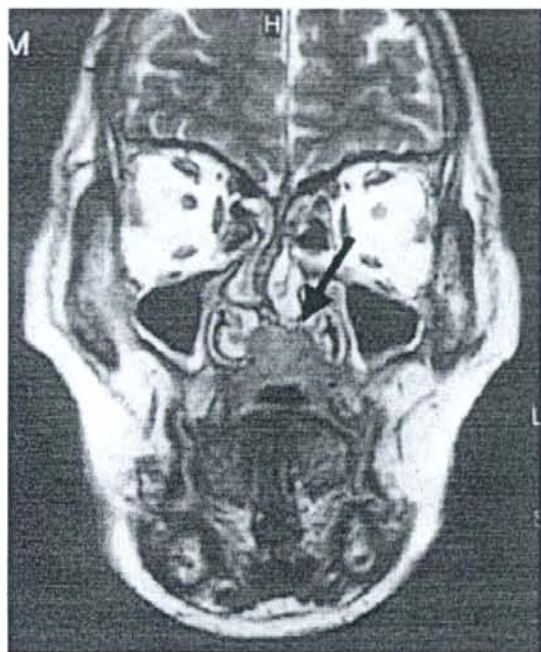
Magnetic resonance imaging showed that the mass had destroyed the palatal bone and invaded the nasal septum and nasal cavity (arrow).
